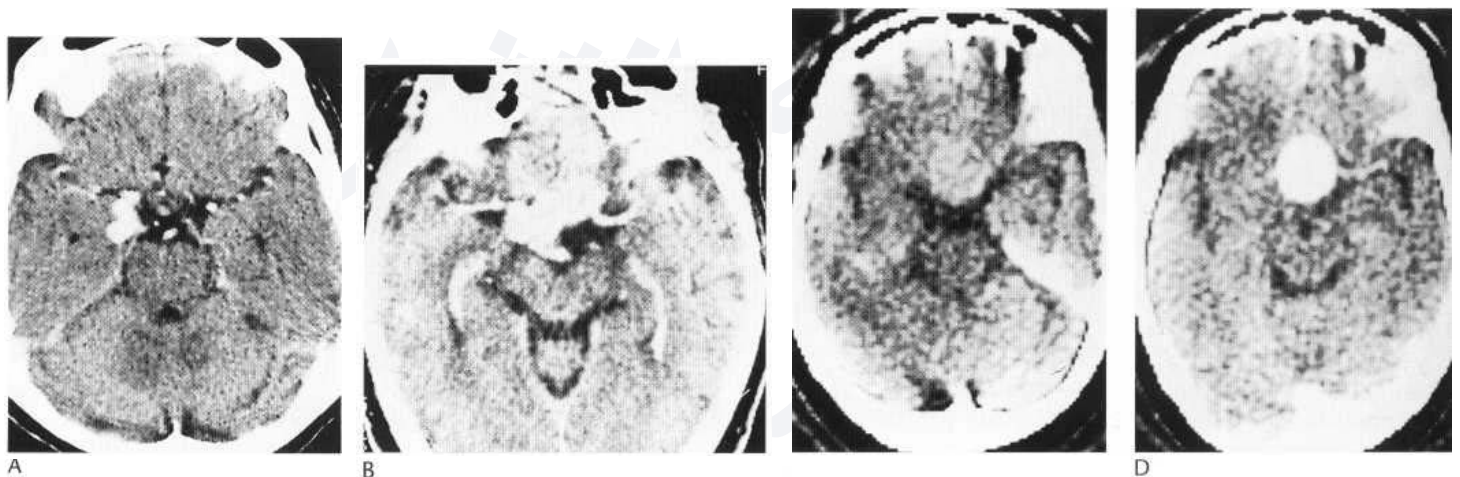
(A) Enhanced CT shows a right posterior communicating aneurysm. (B) Large irregular suprasellar aneurysm after enhancement. (C) High-density rounded mass in suprasellar region. (D) The mass enhances strongly with contrast medium. Large aneurysm confirmed at angiography (L36, W80).
